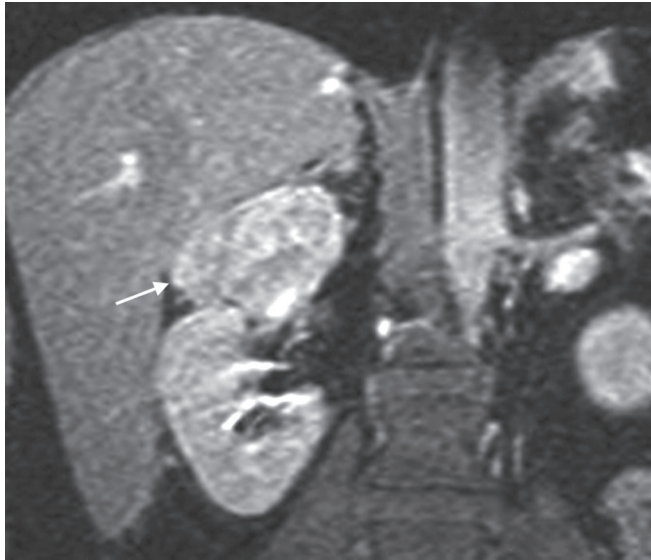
Computed tomography scan of abdomen with intravenous contrast showing large adrenal medullary tumor (pheochromocytoma)
